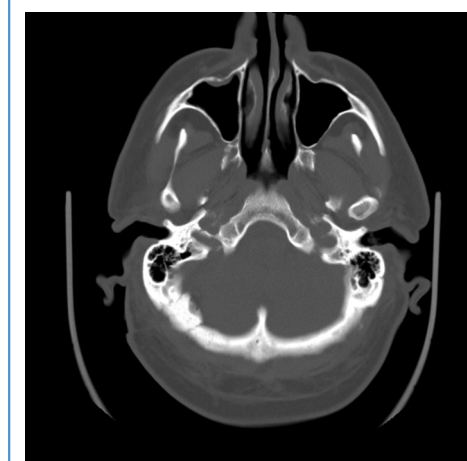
Axial computed tomography showing cement reconstruction of retromastoid occipital bone (right).
